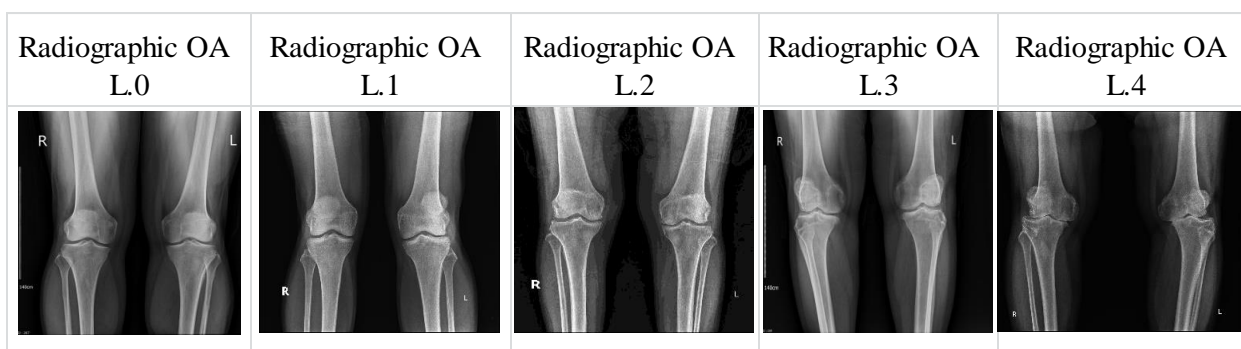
Radiographic OA for inclusion criteria
